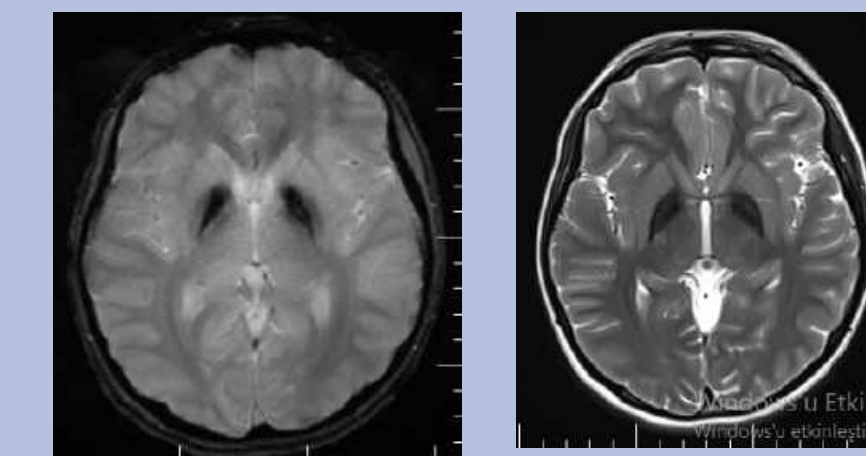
Bilateral hypointensity of globus pallidus and substantia nigra in T2-weighted images
